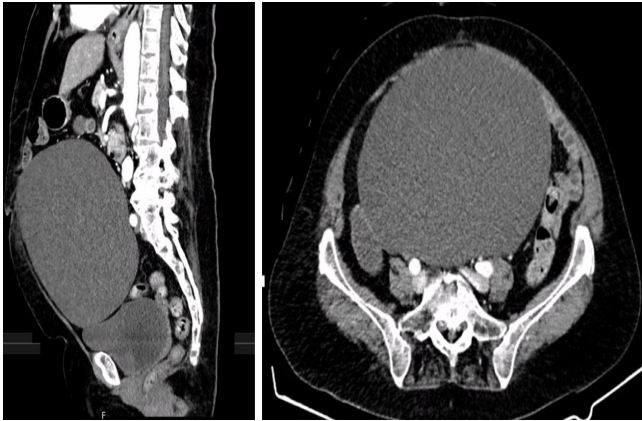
CT-scan (axial and sagittal) revealing a 21 x 15 x 19 cm cystic mass extending from the pelvis to the kidneys, closely associated with the right ovary and compressing nearby structures, including the iliac vessels, right ureter, and bladder.
